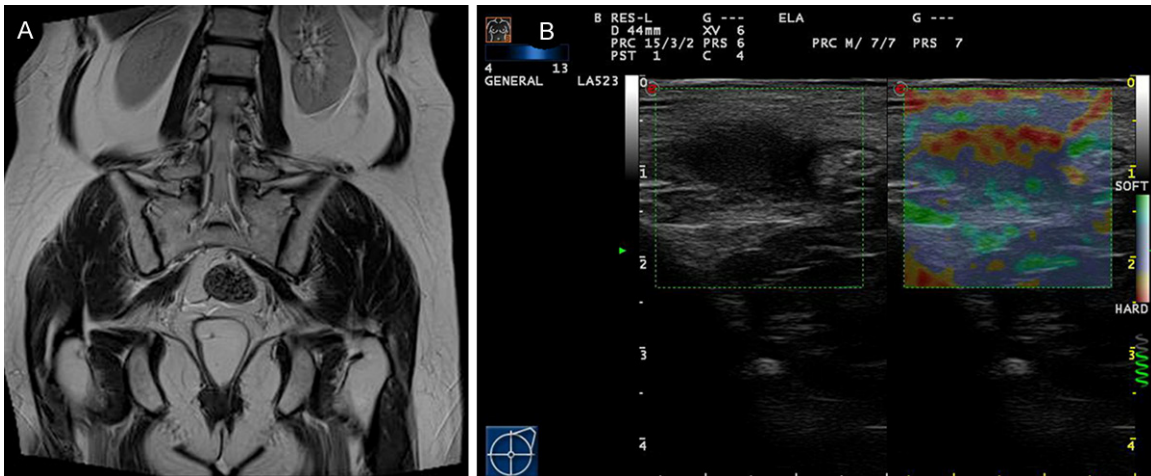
Case 4. A patient of levator ani with no defect detected by MRI (A). ES showed predominantly red and is clearly distinguishable, scored as ES4 (B).
